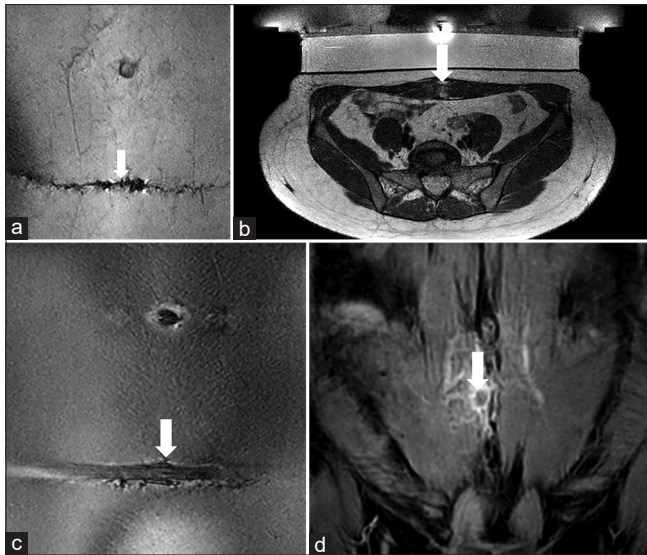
(a) Coronal T2-weighted fast-field echo image shows a long transversal cesarean scar (white arrow). (b) Axial T2-weighted image shows a hyperintense endometriosis lesion inside the right rectus abdominis muscle (white arrow). (c) Coronal T2-weighted fast-field echo image shows a transversal cesarean scar covered with scar path (white arrow). (d) Coronal T1-weighted with contrast enhancement image shows the fully ablated lesion after MRI-guided HIFU treatment (white arrow)
